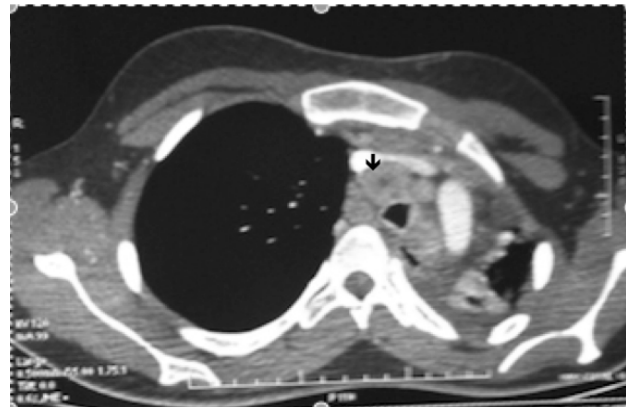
Chest CT-scan showing paratracheal lymph nodes and an endotracheal process
